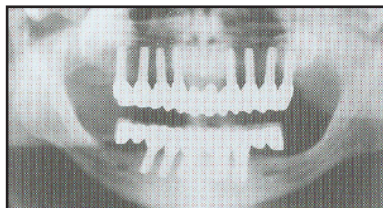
After 4-6 months, a maxillary porcelain-to-metal restoration was delivered. A panoramic radiograph confirmed complete seating.
